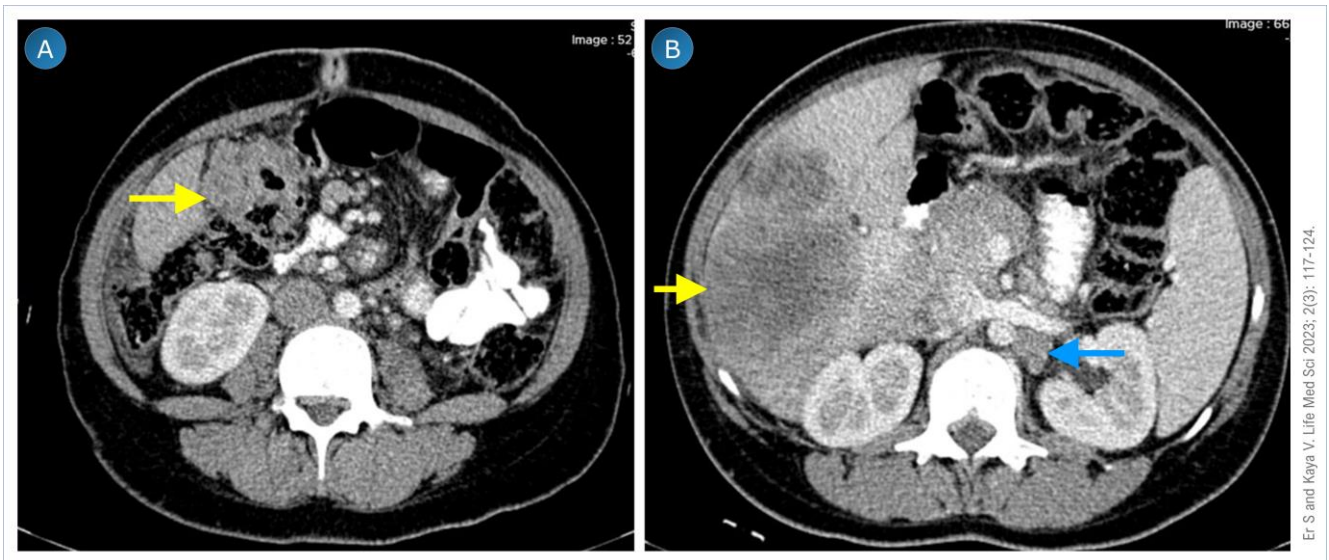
Computed tomography (CT) images of a 28-year-old woman with colorectal cancer and metastases. Abdominal CT images show (A) an advanced mass in the hepatic flexure (arrow), and (B) liver (yellow arrow) and lymph node (blue arrow) metastasis.
